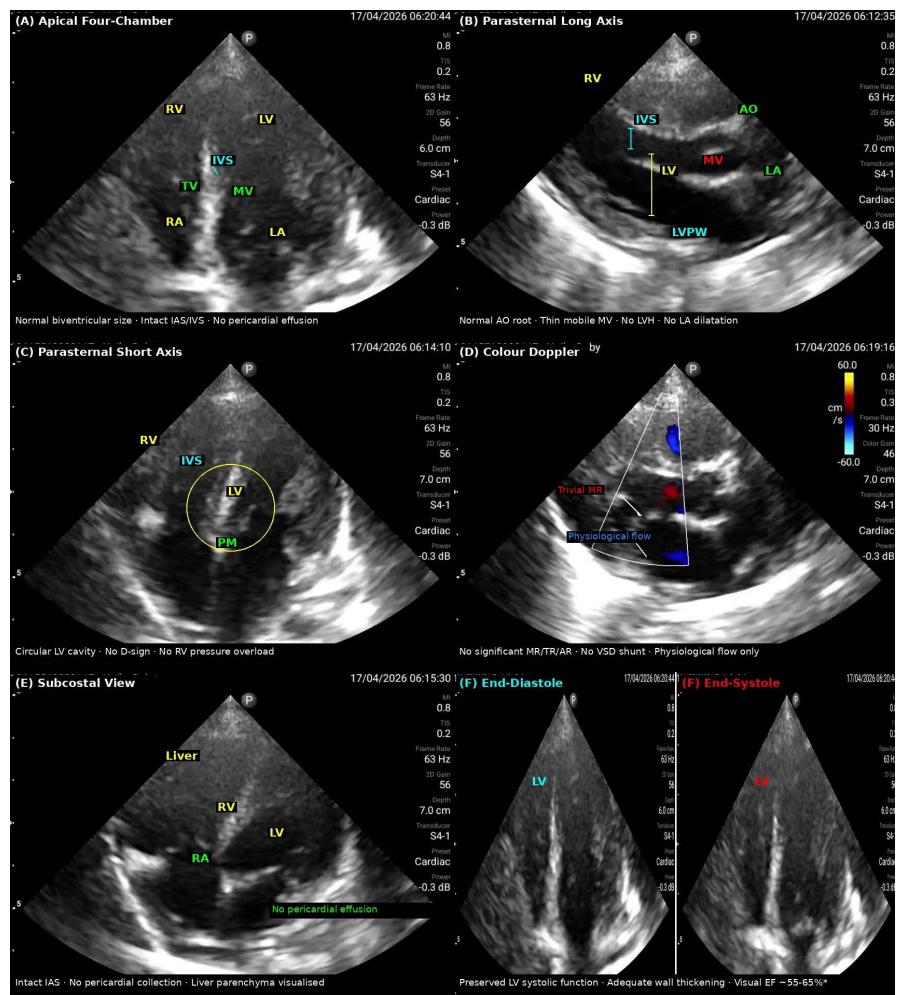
Annotated transthoracic echocardiography—Day 28 (17-Apr-2026). (A) Apical four-chamber: normal biventricular size, labeled LV, RV, LA, RA, IVS, MV, TV. Intact septa, no pericardial effusion. (B) Parasternal long axis: normal aortic root, thin mobile mitral valve, no LVH or LA dilatation. IVS and LVPW measurement lines are shown. (C) Parasternal short axis at papillary muscle level: circular LV cavity (yellow outline) confirming no D-sign and no RV pressure overload. (D) Color Doppler: trivial MR only, no significant valvular regurgitation, physiological transvalvular flow. (E) Subcostal: intact IAS, no pericardial effusion, liver parenchyma visualised. (F) End-diastole vs end-systole: preserved LV systolic function with adequate wall thickening; visual EF ~55% - 65%.* Mindray S4-1 transducer, cardiac preset. *Visual estimate—formal Simpson’s biplane not performed.
